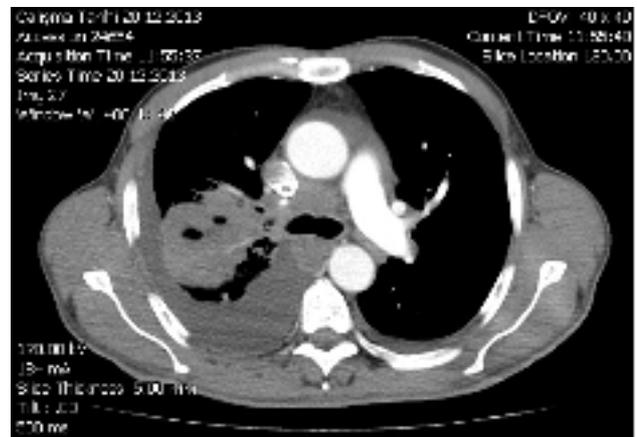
CT scan of the chest with mass lesion measuring 68x51mm in the posterior segment of right upper lobe and bilateral pleural effusion R>L.
